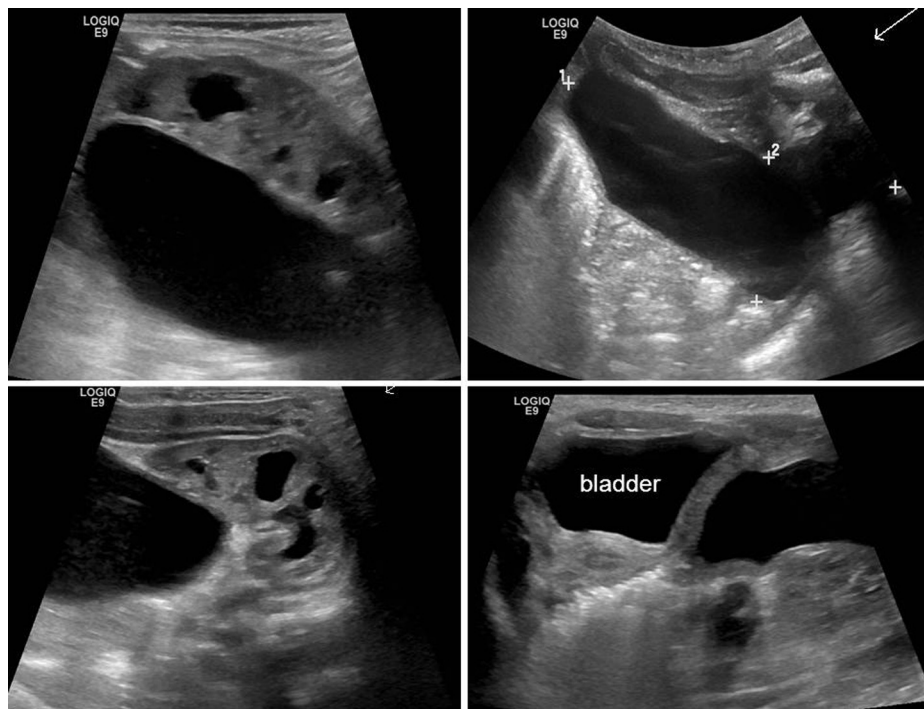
Selected images from abdominal ultrasound showing the cyst and its proximity to the left kidney (left side) and bladder (bottom right).
